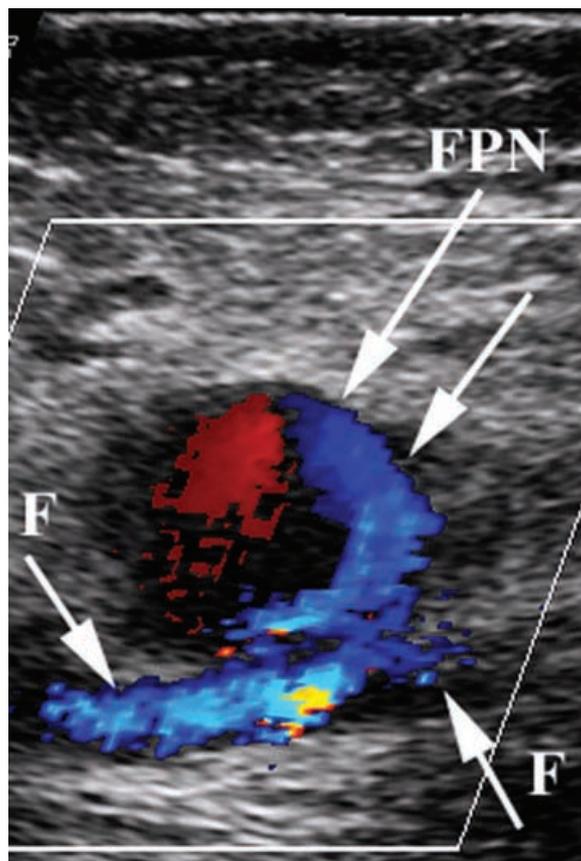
Ultrasound B-mode image and color Doppler of the right femoral artery (F) in a longitudinal view, and a femoral pseudoaneurysm (FPN). Color Doppler reveals a swirling motion within the FPN.
